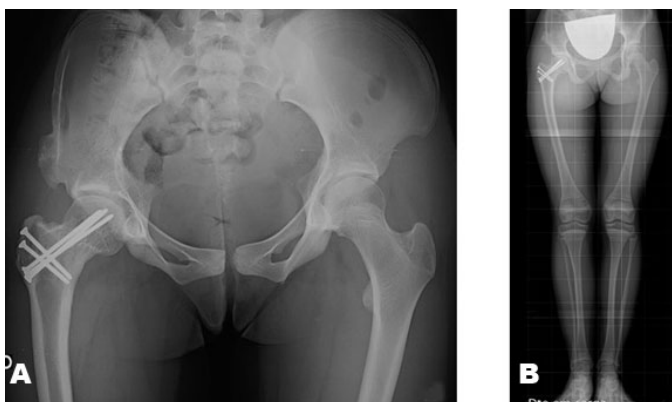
Anteroposterior pelvis X-ray (A) and long leg view (B) (with a right lower limb 24 mm shorter) at five years of post-operative follow-up.
